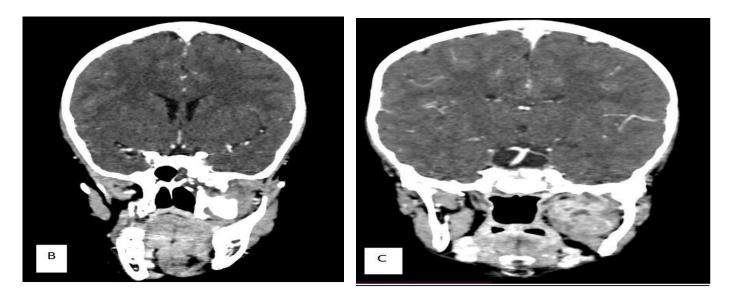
Axial (A) and coronal (B, C)cut of contrast-enhanced CT scan of the neck and head after 6 cycle of chemotherapy, shows significant reduction of tumour size and its mass effect. The tumour in (5) shows more peripheral enhancement with poor enhancement centrally in comparison with prechemotherapy in (1).
